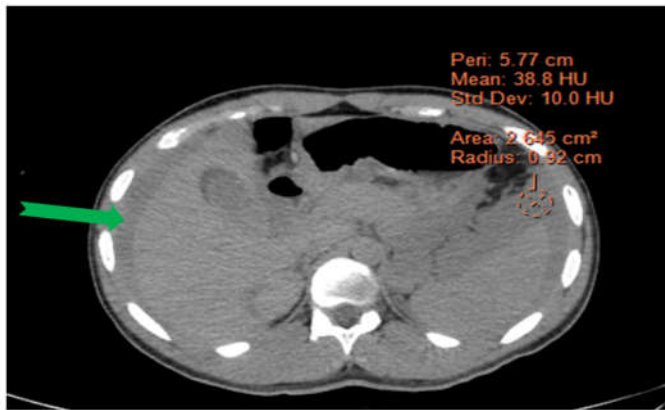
Plain CT showing hemoperitoneum (green arrow pointing fluid- blood)
